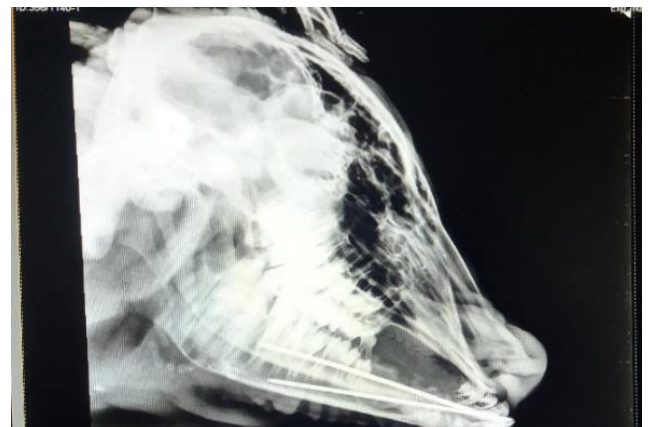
30th Day post-operative radiograph showing callus with no fracture gap
